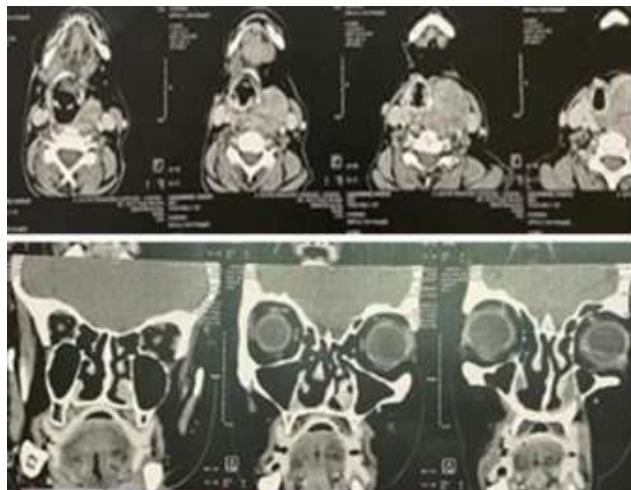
A facial CT scan showing an image of tumoral residue of the nostril cartilage with partial bone invasion of the floor of the nasal fossae and the internalwall of the maxillarysinuseswithout cervical adenopathy.
